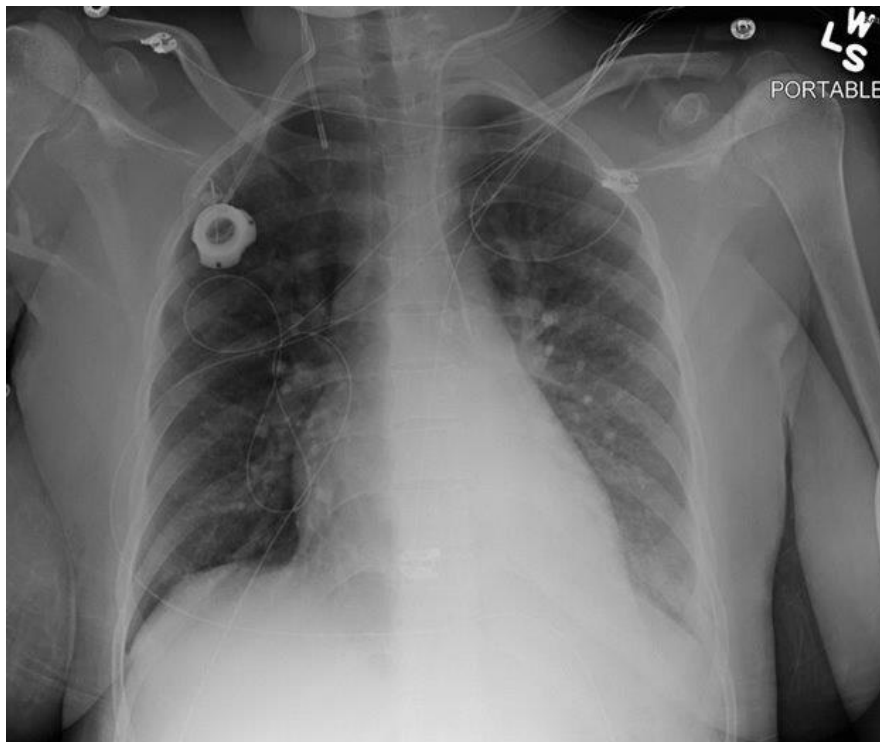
Post CVL insertion chest X-ray
